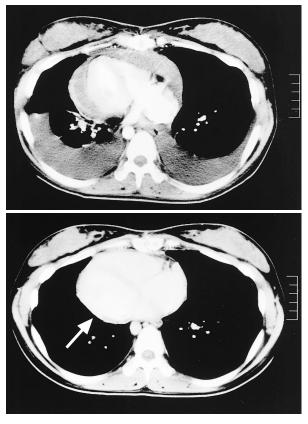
Chest computed tomography scans
